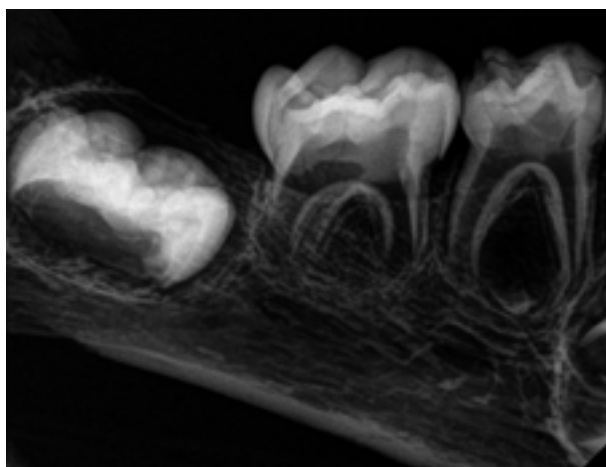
Periapical radiograph depicting the right mandibular deciduous molars and an unerupted permanent first molar.
